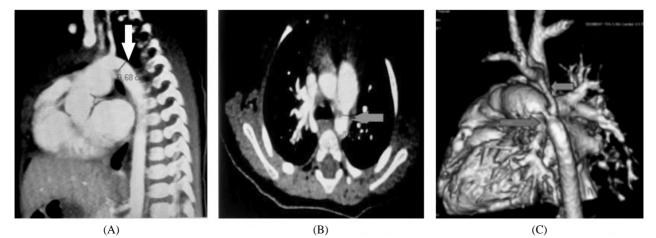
(A) sagittal reconstruction CT images showing the site of isthmic narrowing (whitearrow), (B) Axial CT image showing the site of PDA trunk (blue arrow), (C) 3D reconstructed image showing the site of PDA (yellow arrow) and narrow segment of coarctation (light blue arrow).
